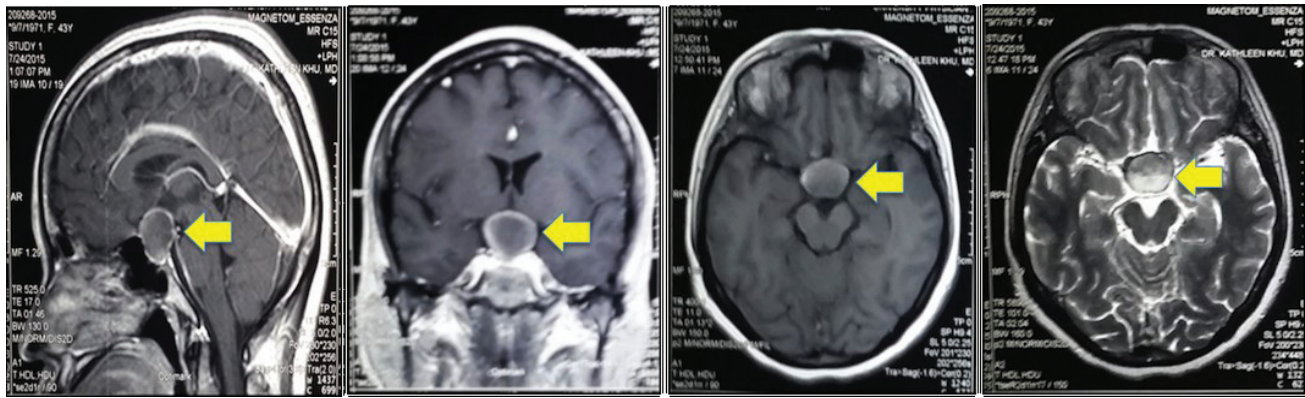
Post-gadolinium MRI showing (arrow) a 2.6 x 2.4 x 1.8 cm round rim-enhancing sellar-suprasellar mass with nodular component and mixed soft tissue and fluid signals compressing the optic chiasm. (a) Sagittal; (b) coronal; (c) isointense on T1W1; and (d) hyperintense on T2W1.
